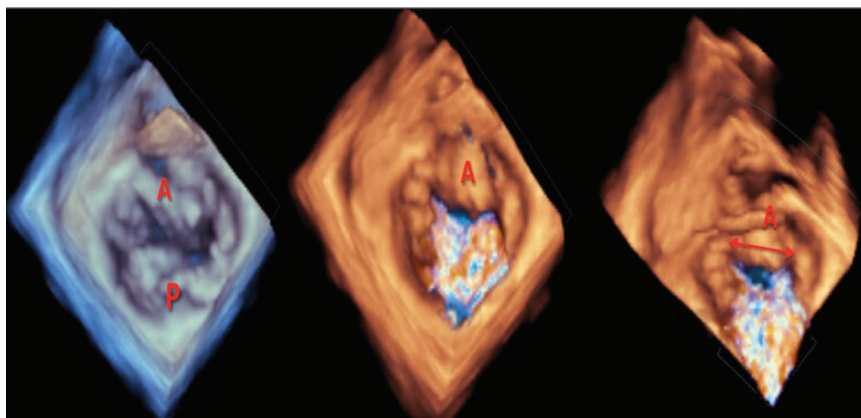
Pattern of regurgitation in patients with atrial MR. On the left is a full-volume acquisition of a mitral valve taken in mid-systole, with colour Doppler removed. Centre pane shows the valve at the same time-point with colour Doppler restored. Note how the regurgitant jet originates along the line of co-aptation. On the right, the image has been tilted. Again note how the regurgitant jet is visible along almost the entire length of co-aptation (arrow). A: anterior leaflet; P: posterior leaflet.
